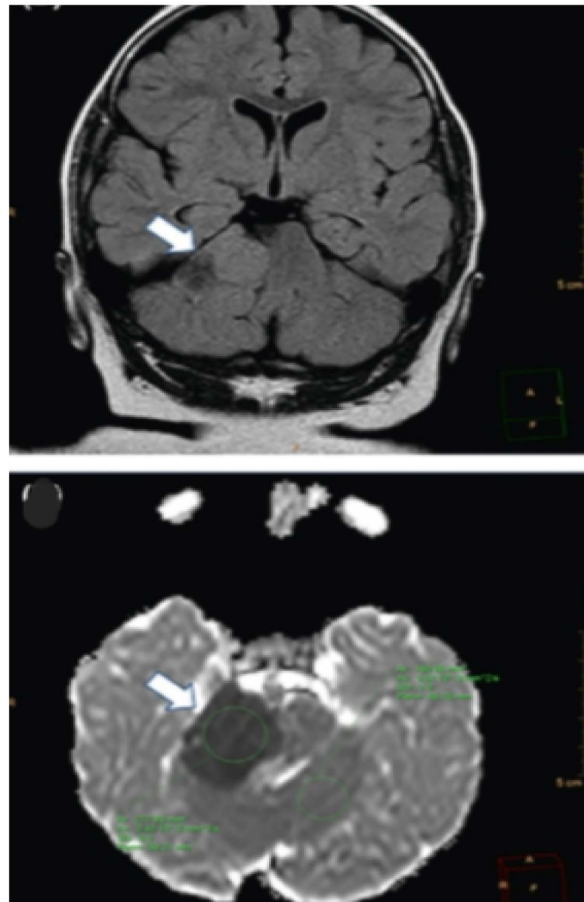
On MRI, the mass was isointense in axial FLAIR imaging and hypointense in axial ADC map.
